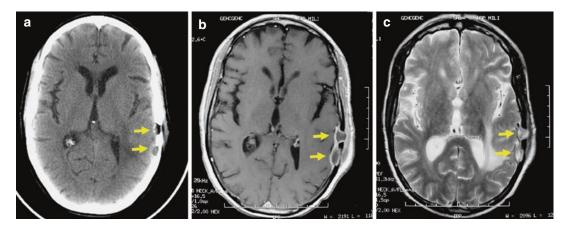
Chronic temporoparietal tuberculous osteomyelitis. Axial cranial CT scan (a), T1-weighted MRI after gadolinium injection (b), and on T2-weighted image
